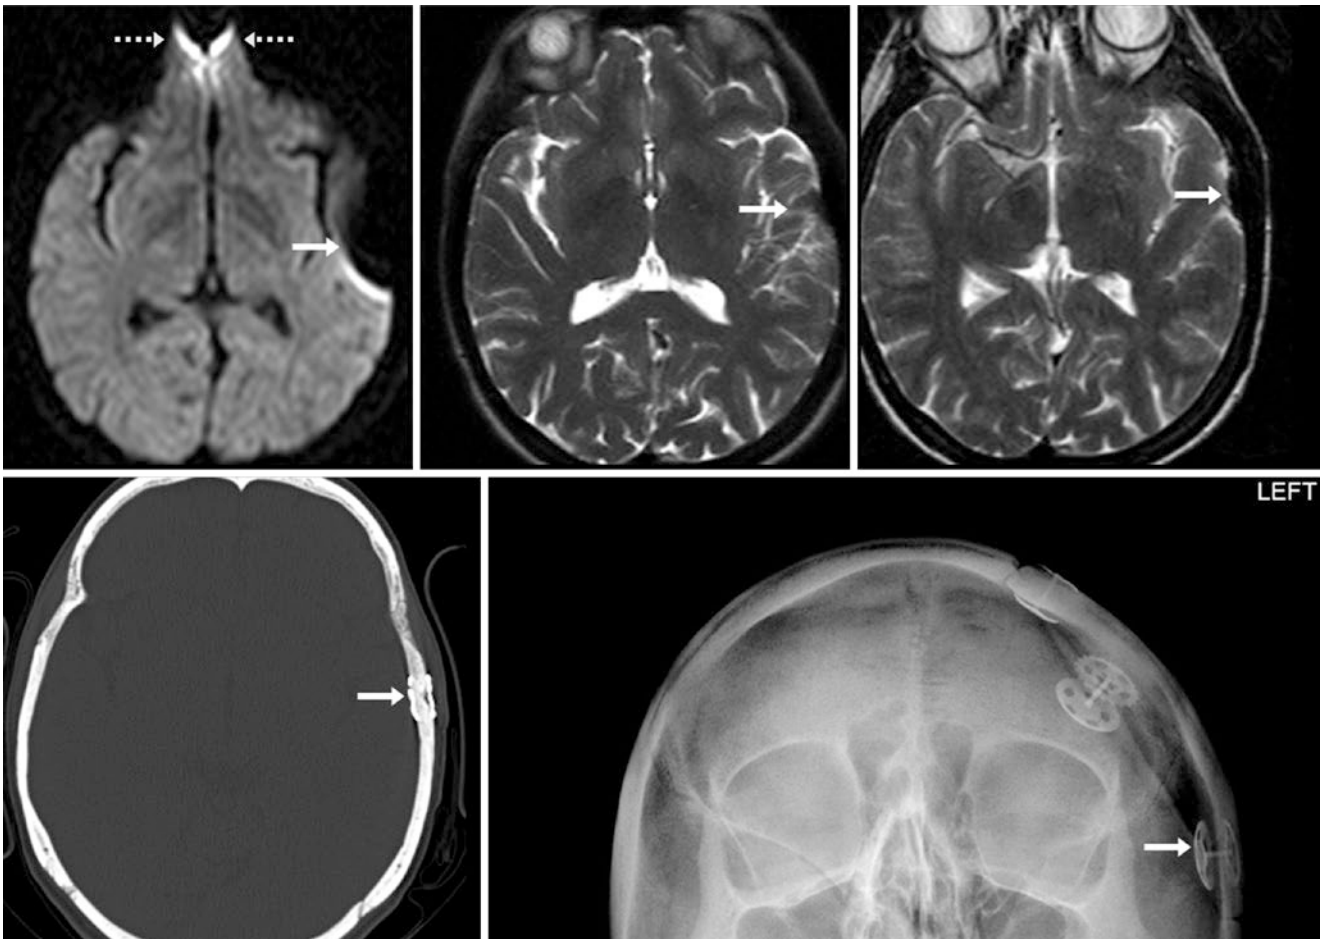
A 35-year-old had craniotomy hardware that caused “blooming” susceptibility artifact (*arrows*) on a 1.5 T DWI MRI (*top left*). The artifact is present to a lesser degree on single-shot T2WI (*top middle*) and is barely notable on turbo spin-echo (TSE, turbo factor of 20) T2WI (*top right*); the artifact is far less on TSE T2WI because the multiple lines used
